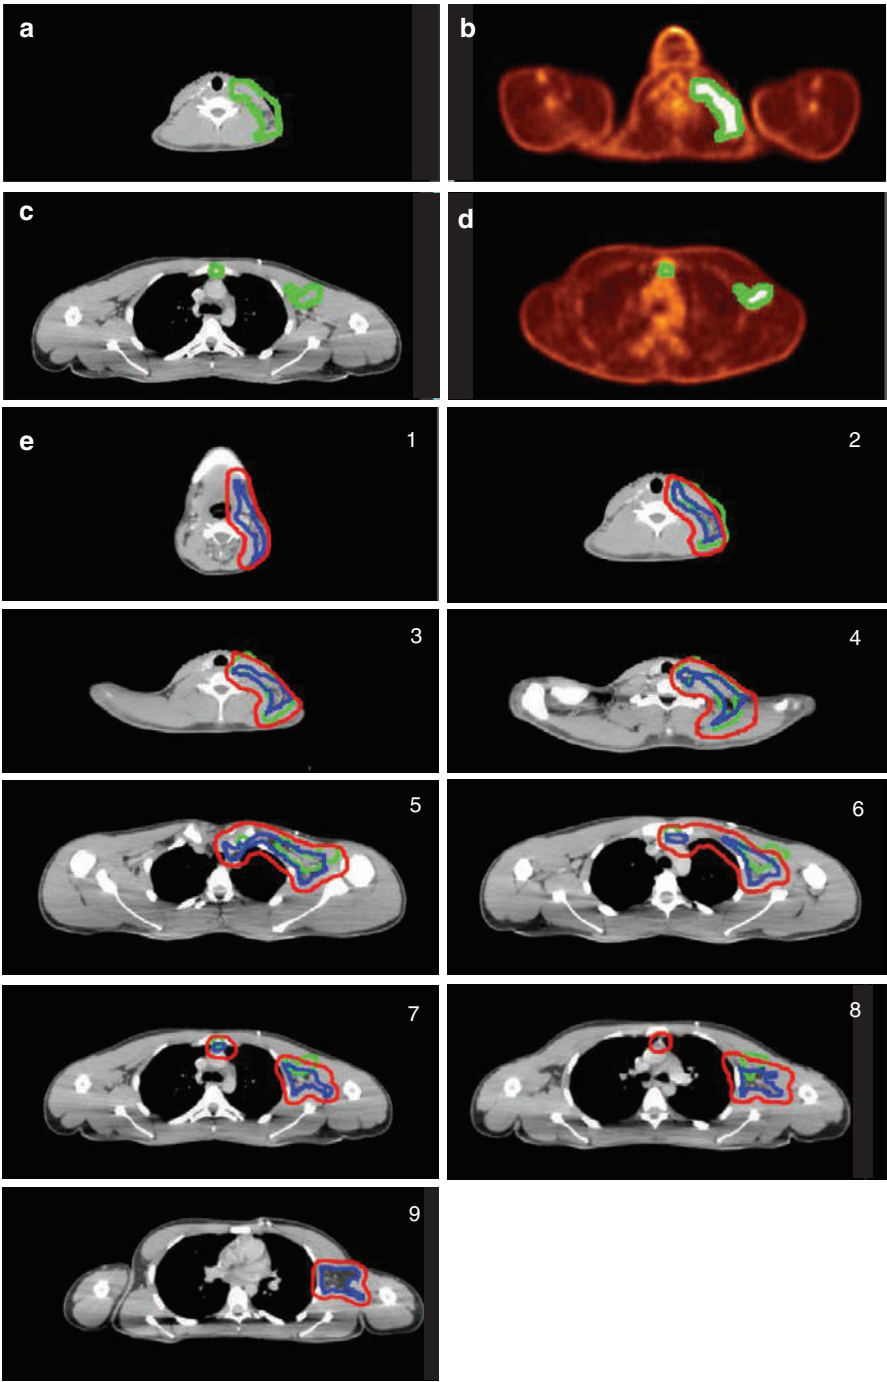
An 18-year-old with nodular sclerosing classical Hodgkin lymphoma with mixed response after chemotherapy. (a) On the radiation planning CT, the green contour depicts the pre-chemo gross tumor disease burden. (b) Pre-chemotherapy diagnostic PET-CT depicting the pre-chemotherapy gross tumor contoured in green. (c) Radiation planning CT with post-chemo GTV contoured in purple. (d) Pre-chemo GTV (green), CTV (blue), and PTV (red) depicted on the radiation planning CT
